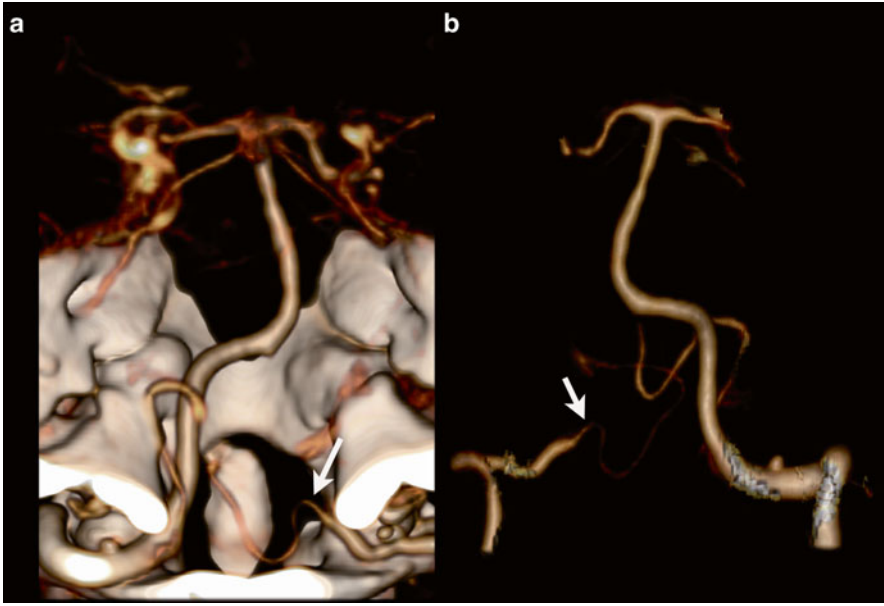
Seventy-four y/o female, CTA performed for evaluation of subarachnoid hemorrhage. Right vertebral artery ends in posterior inferior cerebellar artery. VR-CTA posterior view (a) and VR-CTA after bone-removal anterior view (b) demonstrate a pica ending of the left vertebral artery (arrows)
